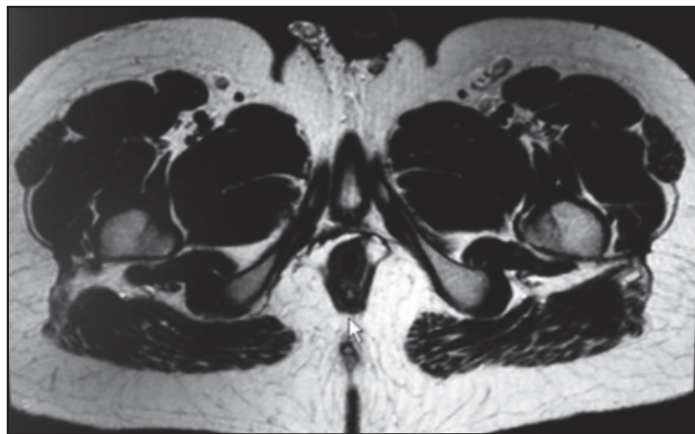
MRI showing presacral cyst
